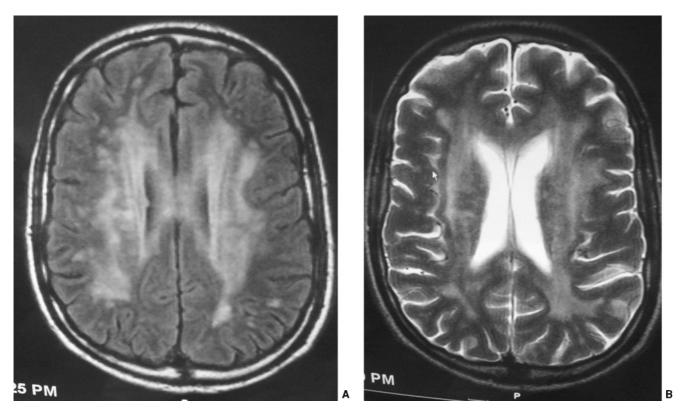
A. ADC (Aids dementia complex): Brain MRI, Flair, of a 32 year old mildly cognitively impaired man, showing periventricular increased signal.
